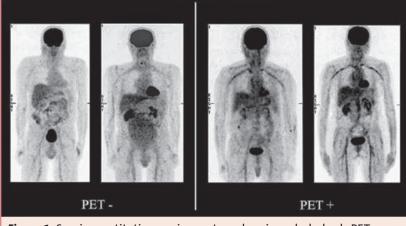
Semi-quantitative scoring system showing whole-body PET scans of patients with no and low-grade (PET-) vascular FDG-uptake (grades 0 and 1) and patients with intermediate-grade and high-grade (PET+) vascular FDG-uptake (grades 2 and 3).
